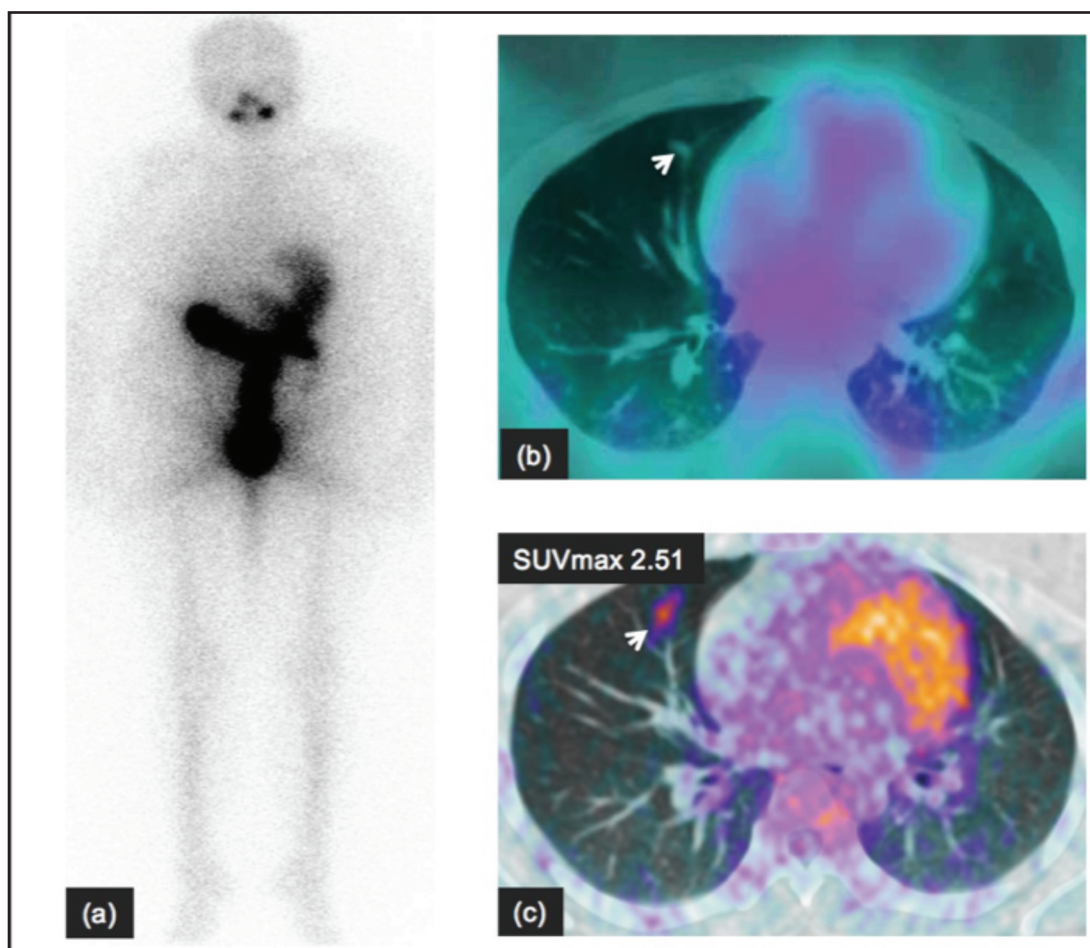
(a) A 18-year-old patient with negative ^{131}I WBS despite high Tg levels. (b) A small, hypodense lung nodule (arrow) detected in the right middle lobe did not demonstrate tracer uptake on the ^{131}I SPECT/CT scan. (c) ^{18}F -FDG PET/CT scan revealed increased tracer uptake in the small lung nodule at the right middle lobe (SUVmax 2.5), indicative of dedifferentiated disease.
